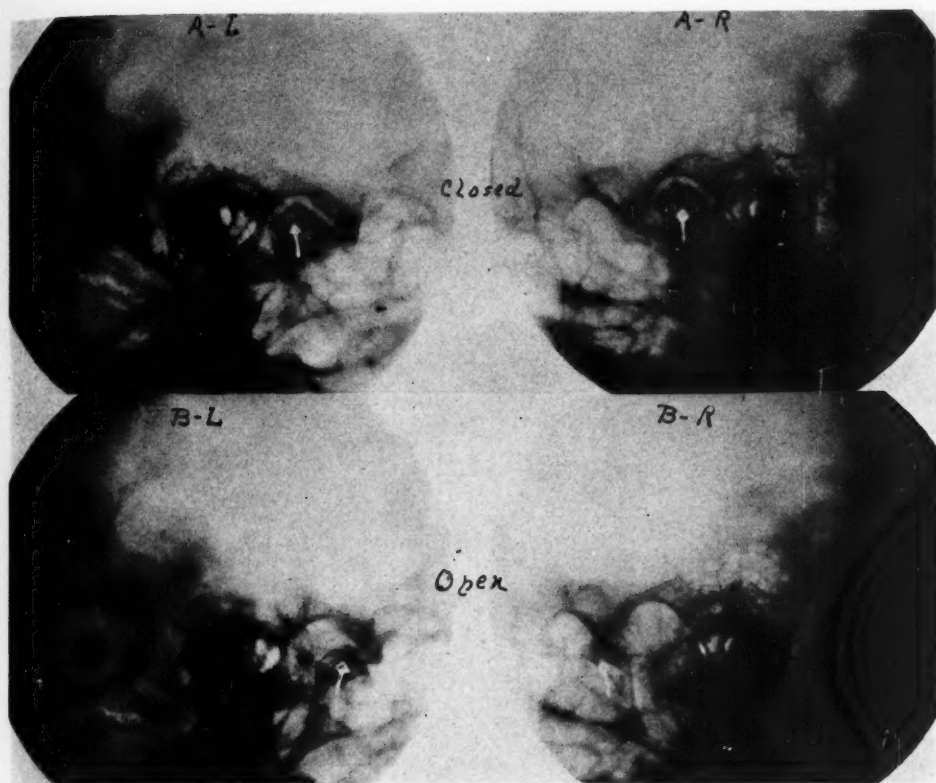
Erosion and flattening of the face of the condyle and the posterior aspect of the tubercle. Case 4, Mrs. S. N., aged 55. *Clinical Symptomatology*.—Pain deep within and about the ears for from 15 to 20 years, appeared on left side, then shifted to right, two years ago it extended to a peri-oral burning or dryness. Extensive studies ruled out any blood dyscrasia or neurological lesion. *Roentgenological Finding*.—Erosion and flattening of the face of the condyles, with co-ordinate angulation of the glenoid fossa, more marked on the left; limitation of excursion of condyles in open position. *Treatment*.—Treatment dentures to replace absent molar teeth, extending vertical dimension slightly more on the left than the right side. *A-L*, Closed position, left mandibular joint; *A-R*, Closed right mandibular joint; *B-L*, Open left mandibular joint; *B-R*, Open right mandibular joint.
